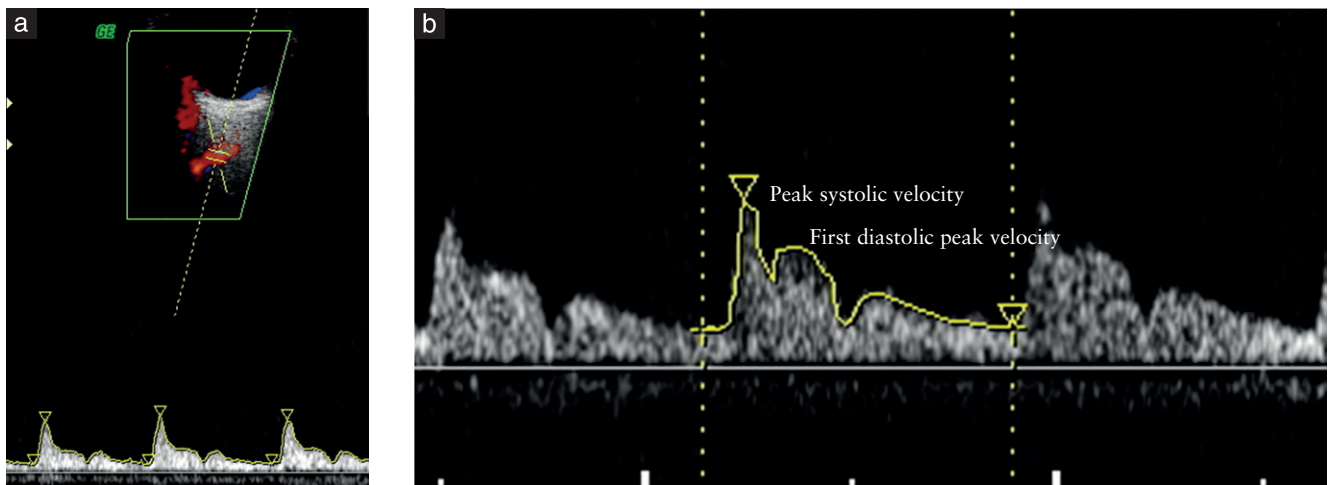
Ophthalmic artery Doppler interrogation (a) and waveform (b).
